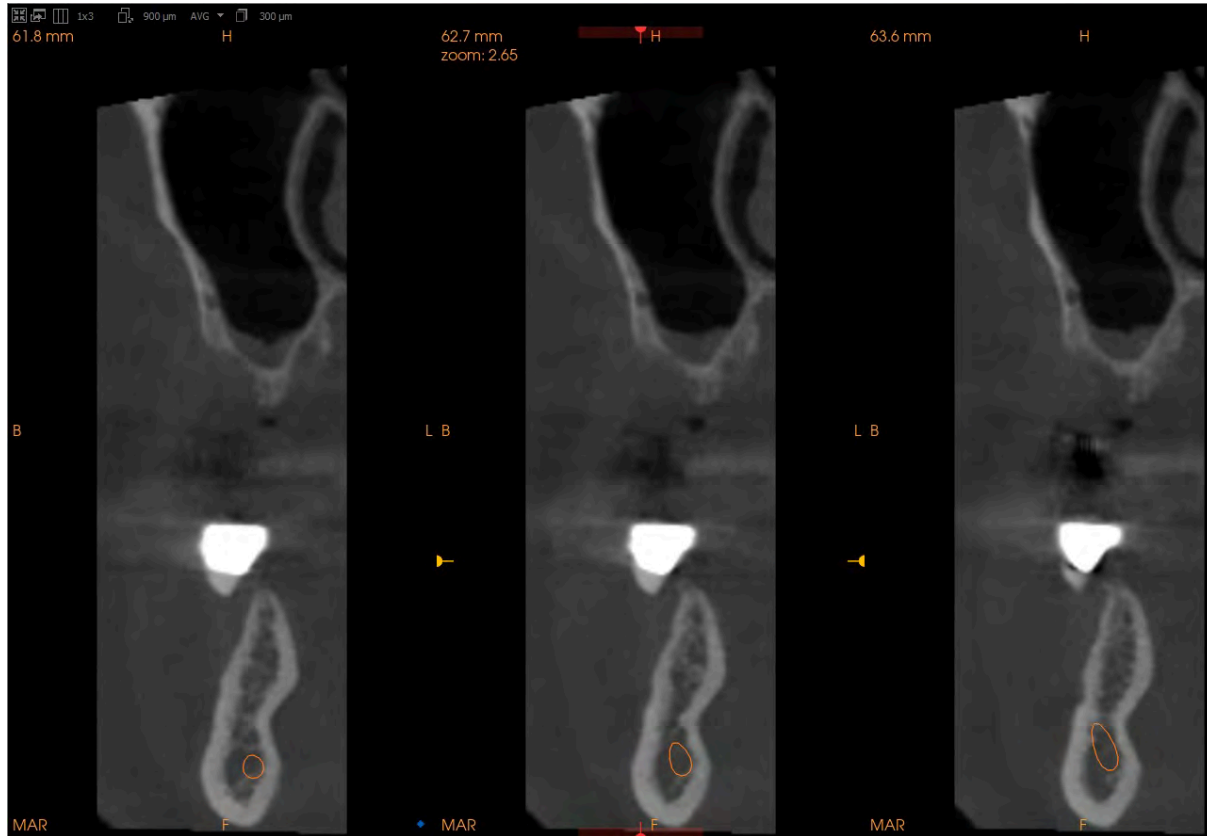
Coronal CBCT section view
